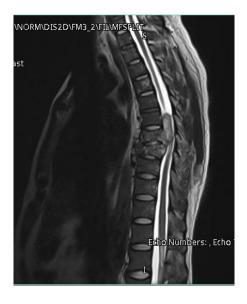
MRI dorsal spine.
